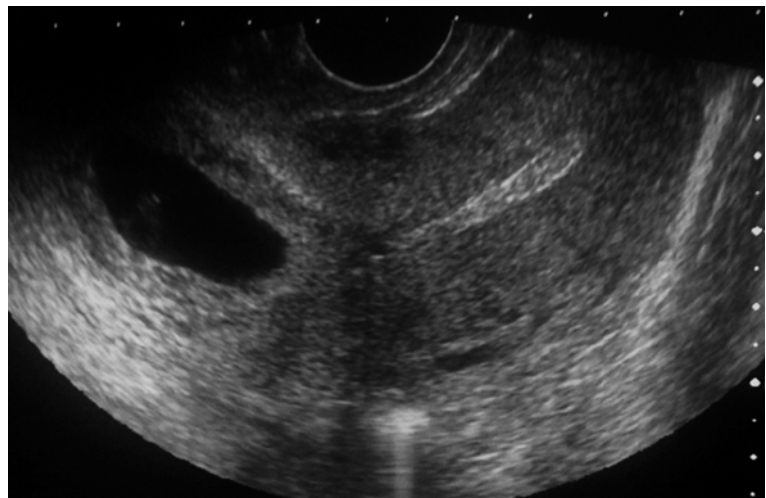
A ultrasonographic sagittal scan showing location of the products of conception below the internal orifice
